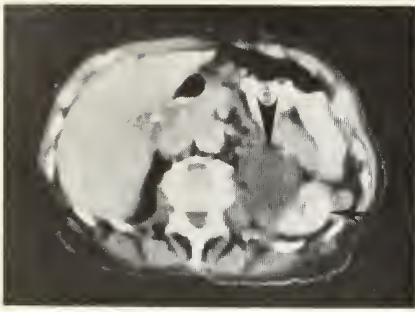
Hydronephrotic left upper renal pole on CT scan.
